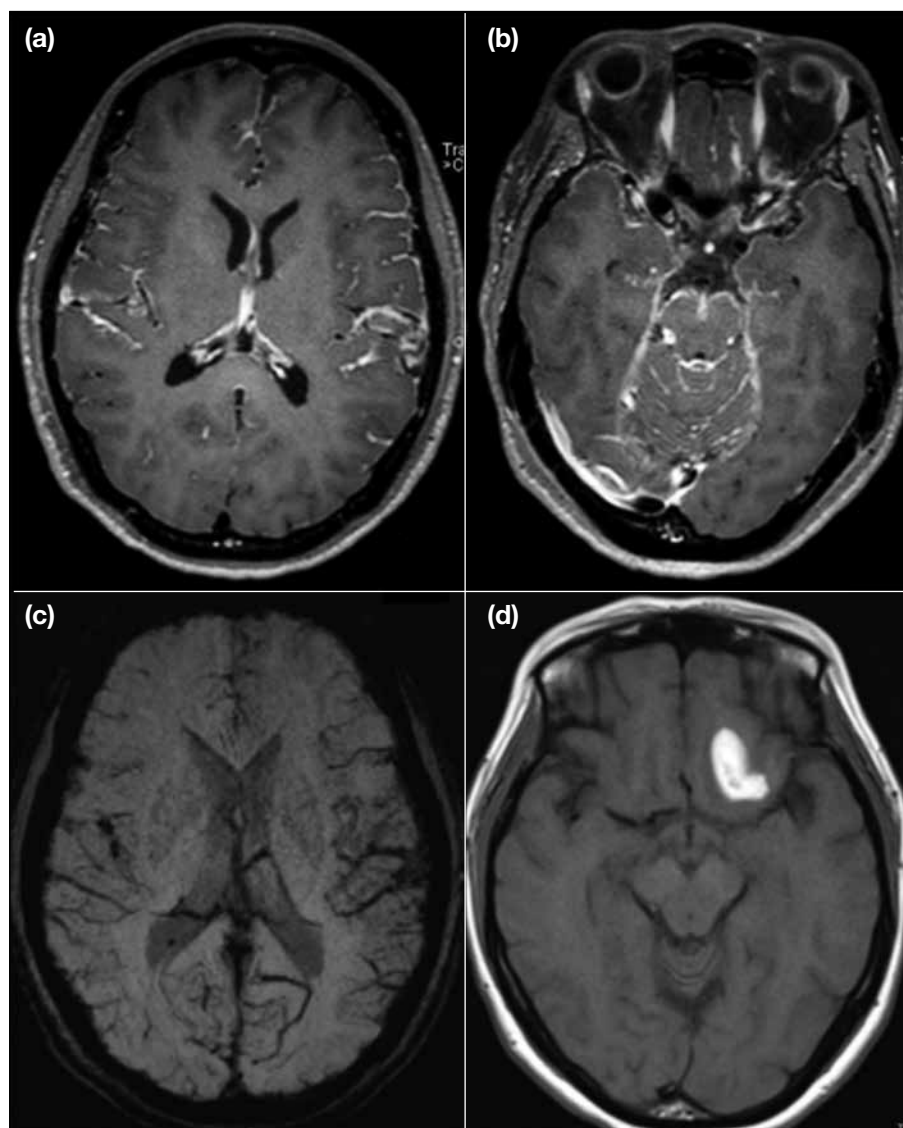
Magnetic resonance imaging (MRI) images of the brain. T1-weighted post-gadolinium axial images of the brain at the level of (a) lateral ventricles and (b) the pons demonstrating diffuse leptomeningeal enhancement involving bilateral cerebral sulci and perimesencephalic region. (c) Susceptibility-weighted image showing diffuse superficial haemosiderosis. (d) T1-weighted axial images of follow-up MRI of the brain 1 month later, showing T1-weighted hyperintense intracerebral haematoma in the left inferior frontal lobe.
